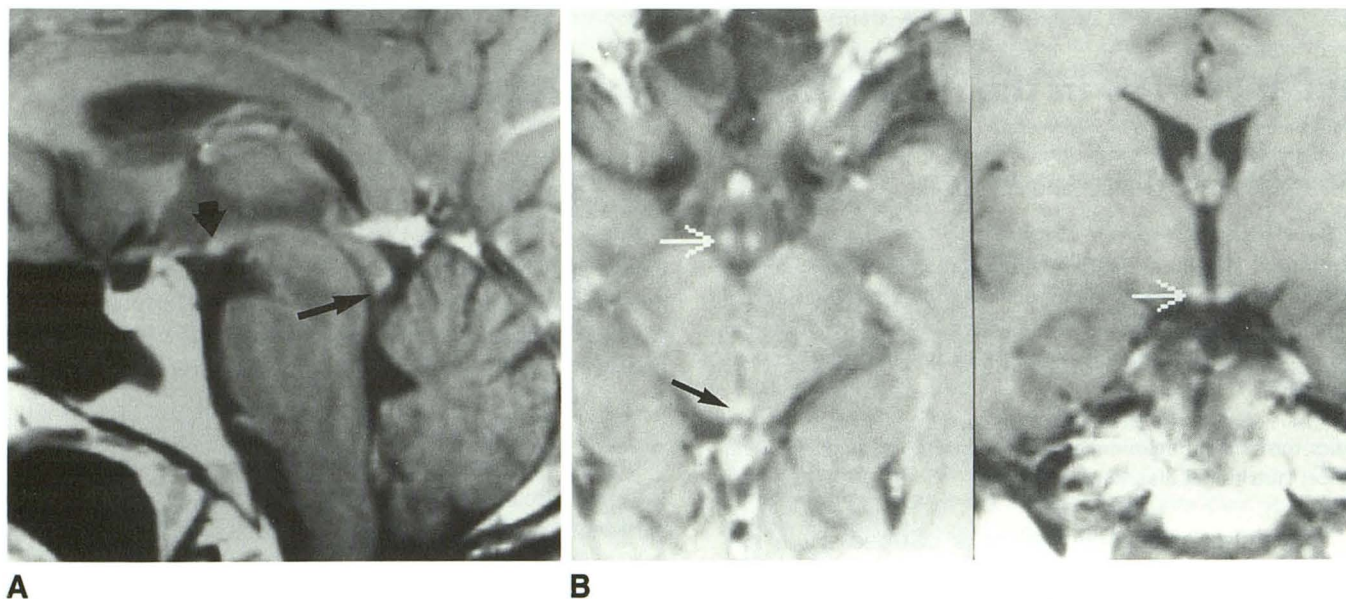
Follow-up MR T1-weighted images in the midsagittal (A) and axial and coronal plane (B) (spin-echo, 500/15) with gadopentetate dimeglumine 2 weeks after institution of therapy show reduction in the size of mamillary bodies and persistent enhancement at the level of the inferior quadrigeminal plate (*thin black arrow*) and mamillary bodies (*wide arrow* and *white arrow*).
